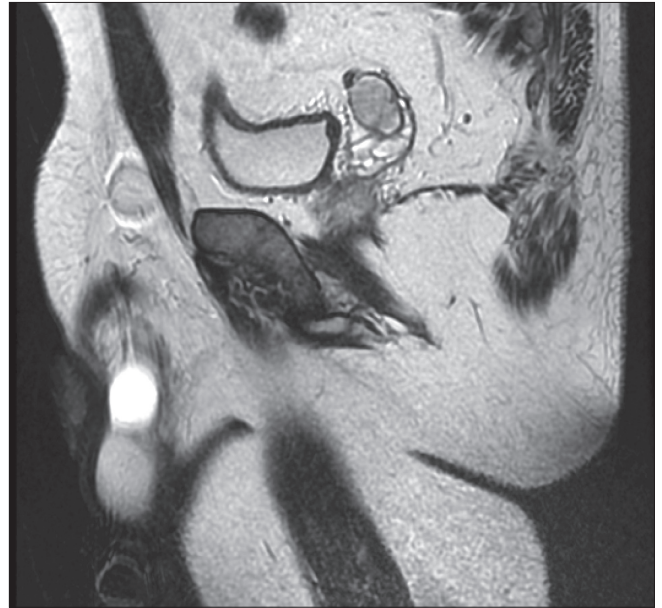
Magnetic resonance imaging parasagittal section.
